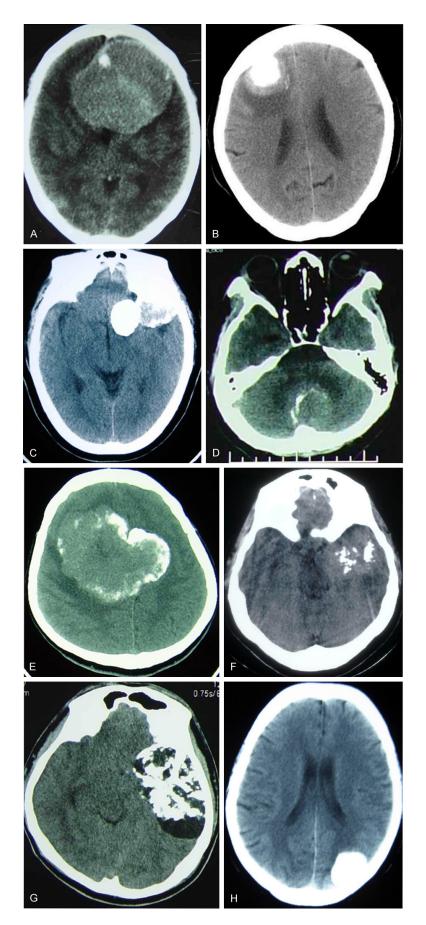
CT imaging of meningioma with different calcification forms. A. Stippled calcification; B. Nodous calcification; C. Cauliflower-like calcification; D. Lamellar calcification; E. Annular calcification; F. Island-like calcification; G. Diffuse calcification; H. Complete calcification.
